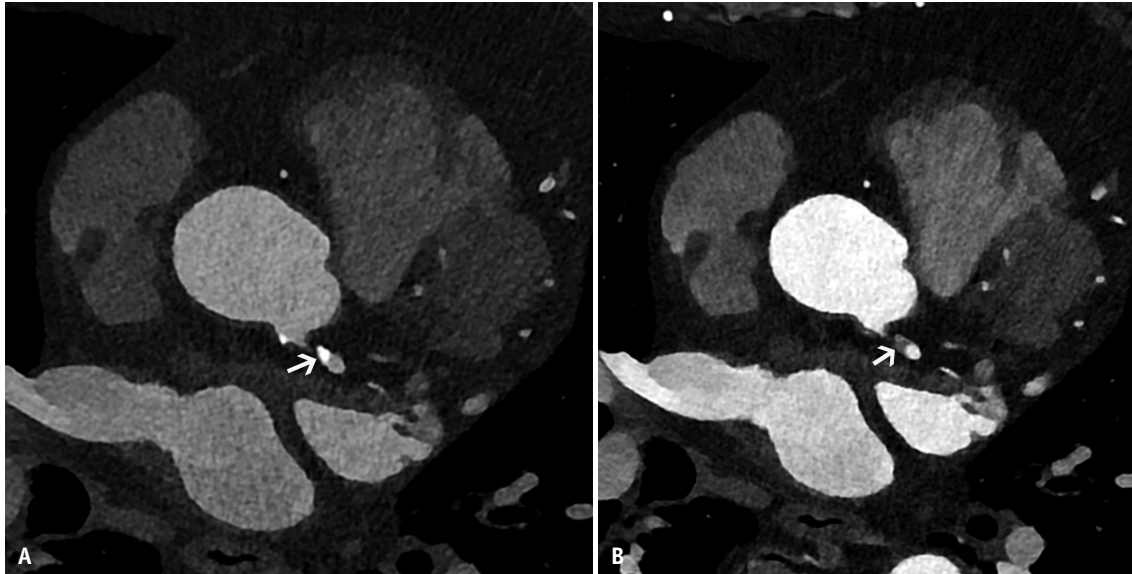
Material-based calcium separation. A: Coronary CT angiography from photon-counting CT in a 75-year-old female shows dense calcified plaque in the left main coronary artery (arrow) with moderate stenosis. B: Virtual non-calcium reconstruction (PureLumen) using a three-material decomposition algorithm replaces calcium pixels with gray color (arrow), mitigating the effect of calcium blooming and improving stenosis assessment.
